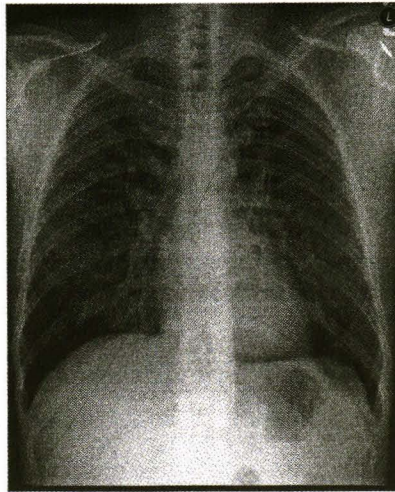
A chest radiograph revealed diffuse bilateral reticulonodular infiltrates.
